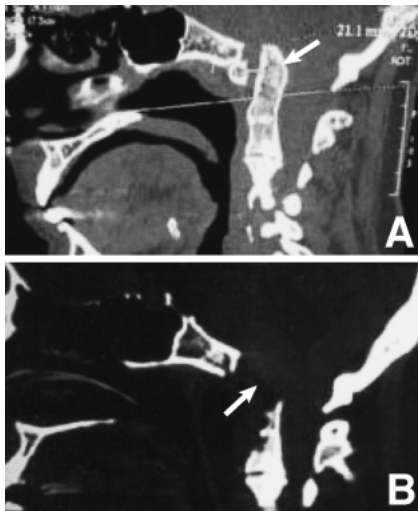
Case 2. Sagittal bone window computed tomography scans (A) before (arrow) and (B) after odontoidectomy (arrow).
